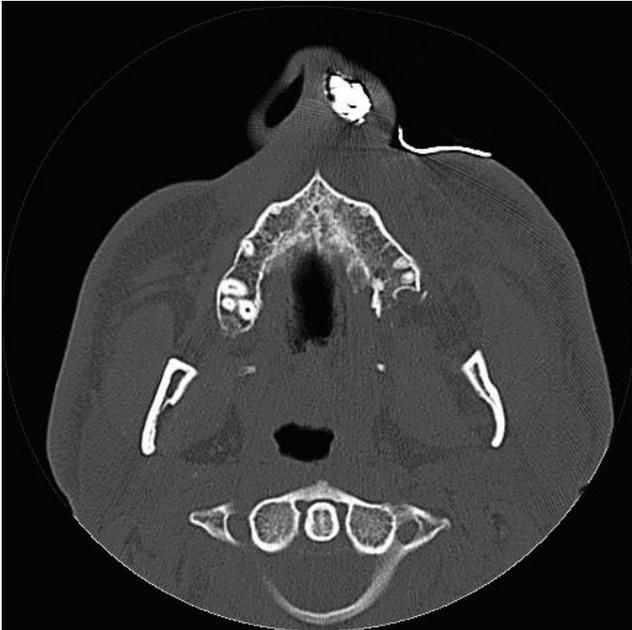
Postoperative CT scan demonstrating maxillary tuberosity fracture posterior to the root apices of the left first molar. Note radiopaque nasal packing *in situ*.
